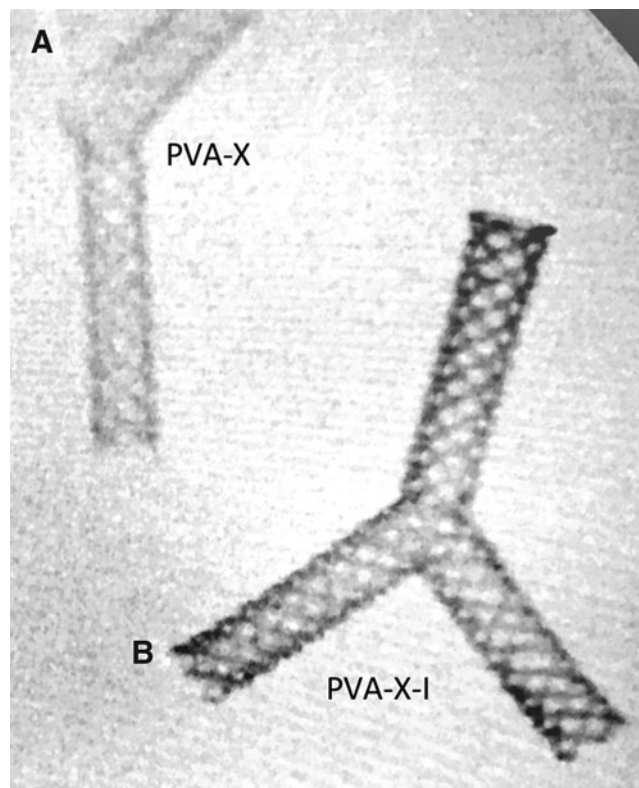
X-ray images of (A) PVA-X and (B) PVA-X-I.
